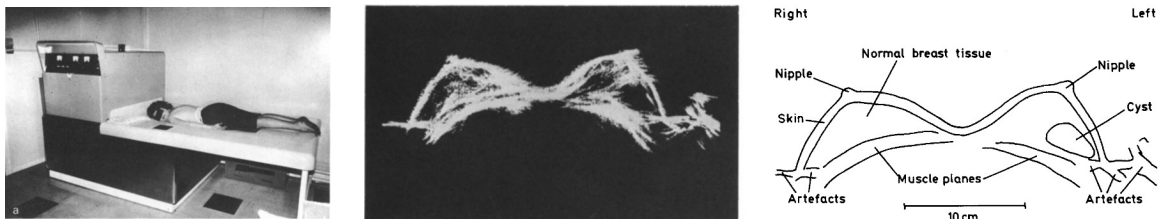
Ultrasound tomography breast scanner and first results from Wells and Evans (1968). [Left] First ultrasound scanning device in which the breasts are suspended in a temperature-controlled water bath. The patient is placed in a prone position. [Middle] Transverse B-scan of a patient’s breasts in the first clinical tests. [Right] Interpretation of the shown B-scan.
